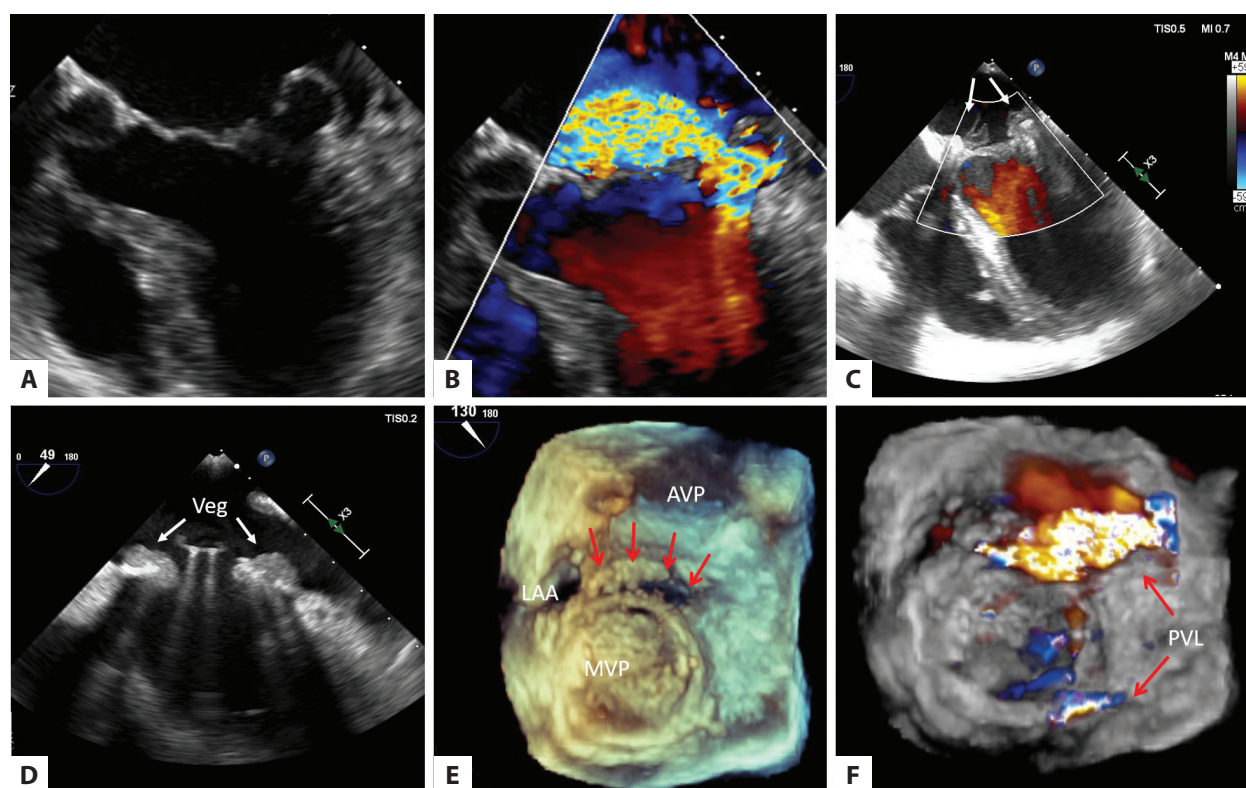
Transesophageal echocardiography: A–B. Preoperative study showing posterior mitral leaflet prolapse with severe MR; C. Control study post mitral valve repair — there is no MR but massive vegetations (Veg) are visible (the white arrows); D–F. Next study after AVP and MVP implantation and CorMatrix reconstruction of the aorto-mitral curtain — recurrence of endocarditis and PVLs are visible (the red arrows). Abbreviations: AVP, aortic valve prosthesis; LAA, left atrium appendage; MR, mitral regurgitation; MVP, mitral valve prosthesis; PVL, paravalvular leak
